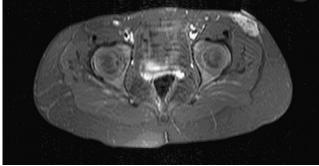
Magnetic resonance image of the upper thighs shows a mass (measuring 4.0×2.0 cm) overlying the left tensor fascia latae and gluteus medius musculature. The tumor demonstrates post-gadolinium enhancement. Small inguinal lymph nodes are present; the largest measures ~ 0.7 cm in the left inguinal chain.
